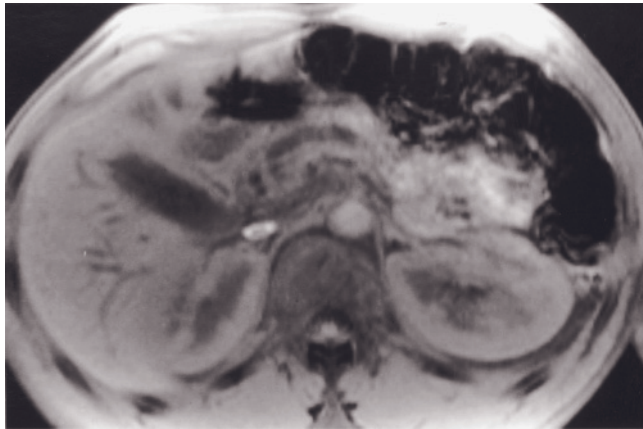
(*Continued*) T2-weighted SS-ETSE (*i*), T1-weighted fat-suppressed SGE (*j*), immediate postgadolinium fat-suppressed SGE (*k*), and 90-s post-gadolinium fat-suppressed SGE (*l*) images in a third patient show the same findings of moderately severe pancreatic ductal dilatation with parenchymal signal intensity changes of chronic pancreatitis.
